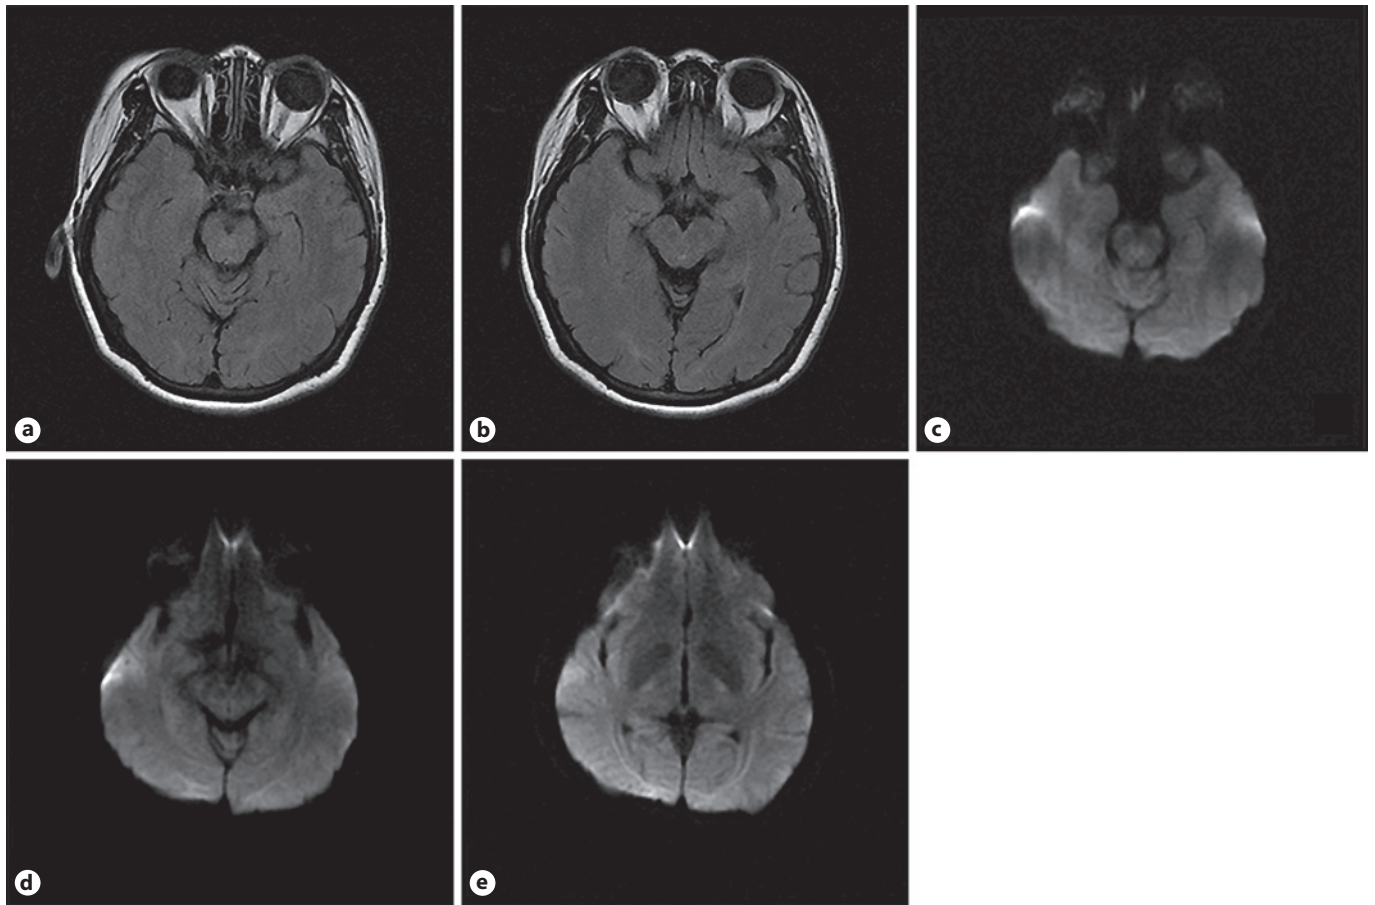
Brain MRI of the other structures. a, b Brain fluid-attenuated inversion recovery imaging shows no abnormalities in the temporal lobe, hippocampus, amygdala, thalamus, or basal forebrain. c–e Axial diffusion-weighted imaging depicts the integrity of the fornix, medial temporal lobe memory structures, and diencephalic memory structures. MRI, magnetic resonance imaging.
